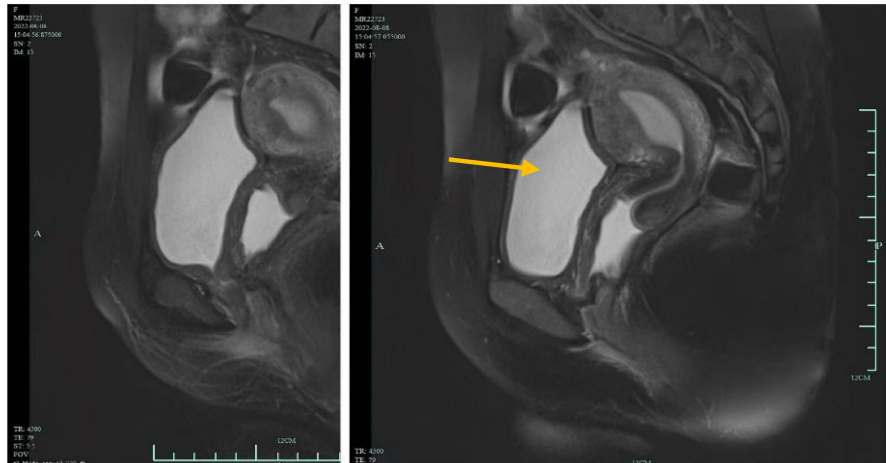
Pelvic MRI arrow showing cystic dilation of the upper vagina.
